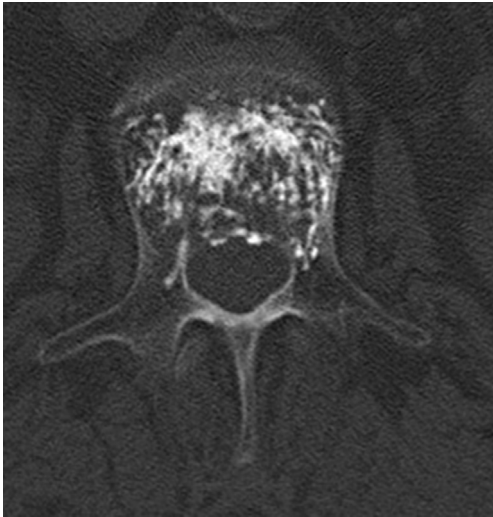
Postoperative axial CT scan revealing the interdigitation of VK100 without destroying the trabecular structure.
